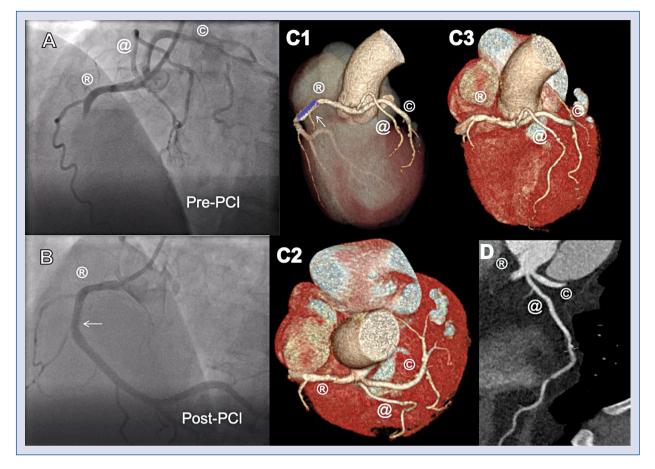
Coronary angiography pre-percutaneous coronary intervention (A) and post-percutaneous coronary intervention (B). Computed tomography coronary angiography showing right coronary artery, left anterior descending artery and left circumflex artery arising from the right coronary cusp on three-dimensional reconstruction (C1, C2, C3; white arrow indicates stented segment) and multiplanar reformation (D).
